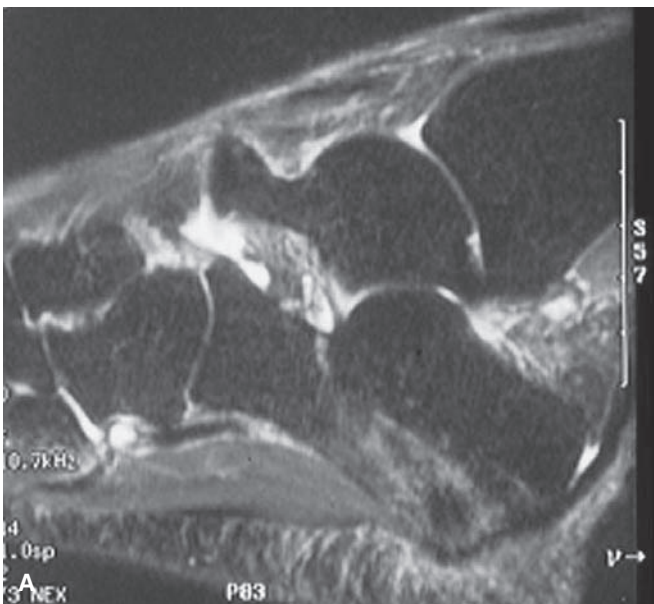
A: MRI showing stress fracture from plantar fasciitis. B: X-ray showing bilateral stress fractures from osteoporosis. Note the difference in fracture orientation.
